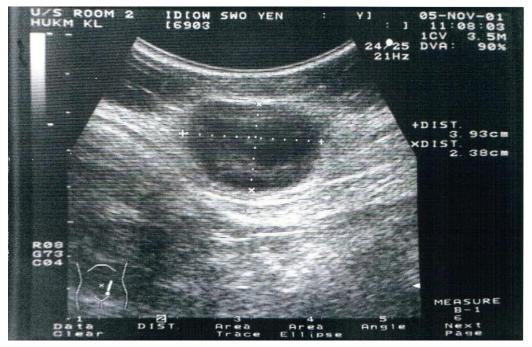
Ultrasound showed a fairly well defined inhomogenous soft tissue mass, measuring about 4x4x2.6cm in the deep subcutaneous region in left iliac fossa
